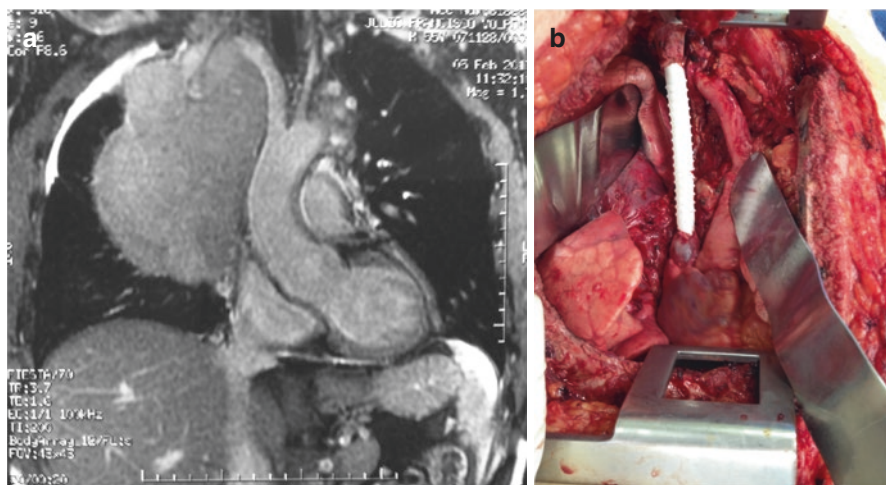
(a) CT scan of a thymoma with invasion of the superior vena cava. (b) Revascularization of the right innominate vein/superior vena cava using a ringed PTFE graft
